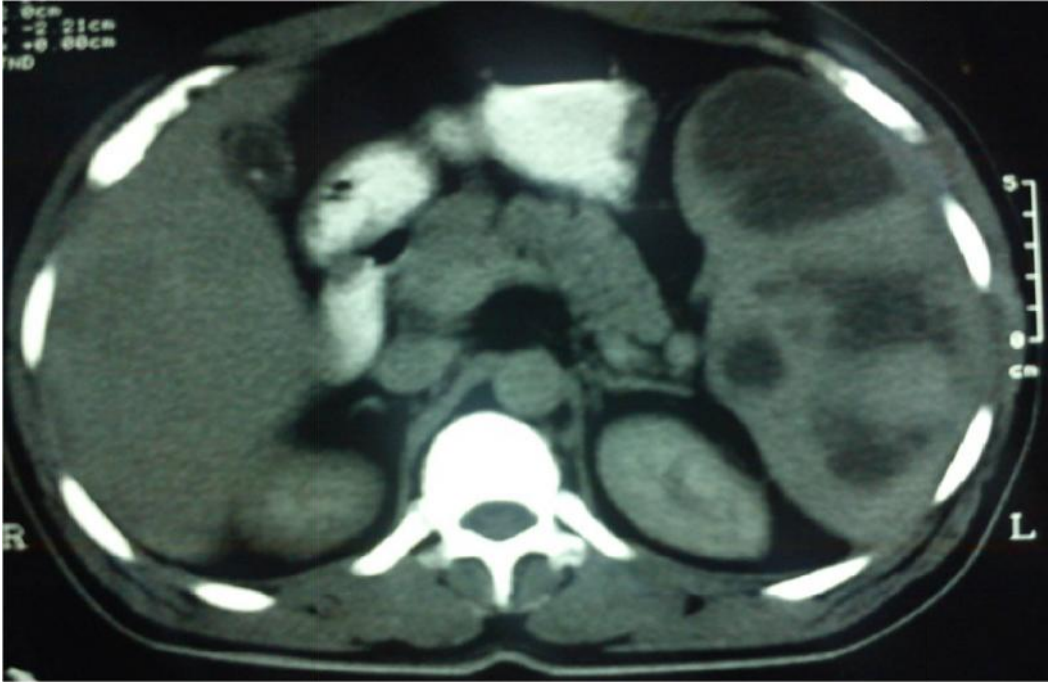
CT ABDOMEN SHOWING MULTIPLE SPLENIC ABSCESS
